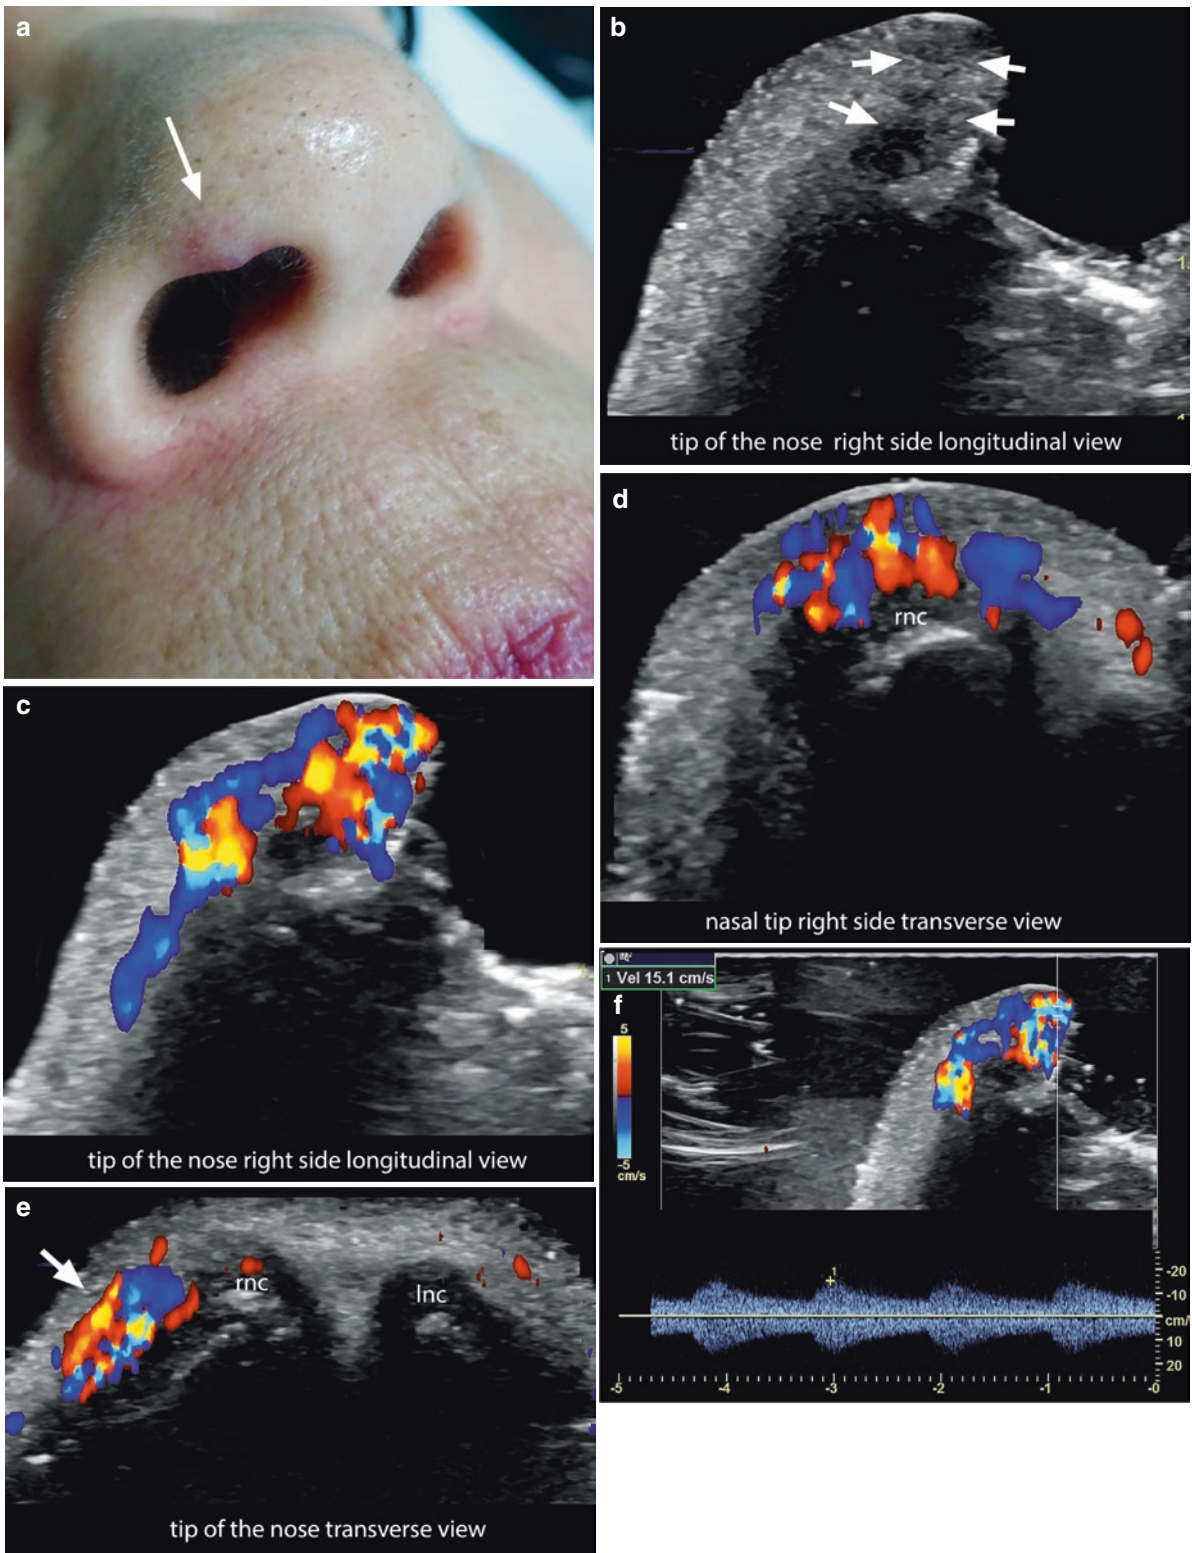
High-flow arterial vascular malformation. (a) Clinical image shows a lesion (*arrow*) in the right side of the tip of the nose. (b) Greyscale ultrasound; (c–e) Color Doppler ultrasound. (f) Spectral curve analysis of the blood flow in the same region. An ill-defined, hypoechoic dermal area in Greyscale (b, *arrows*) clearly becomes a network of tortuous dermal vessels on color Doppler (c, longitudinal view; e, transverse view). The dermal hypervascularity at the anterior aspect of the right nostril involves the surface of the right alar nasal cartilage (c–e). In the spectral curve analysis (f), the peak systolic velocity is 15.1 cm/s, which is a high velocity for the dermis. Notice that there is no mass-like structure between the vessels. *rnc* right alar nasal cartilage, *lnc* left alar nasal cartilage. See Video 4.12.
